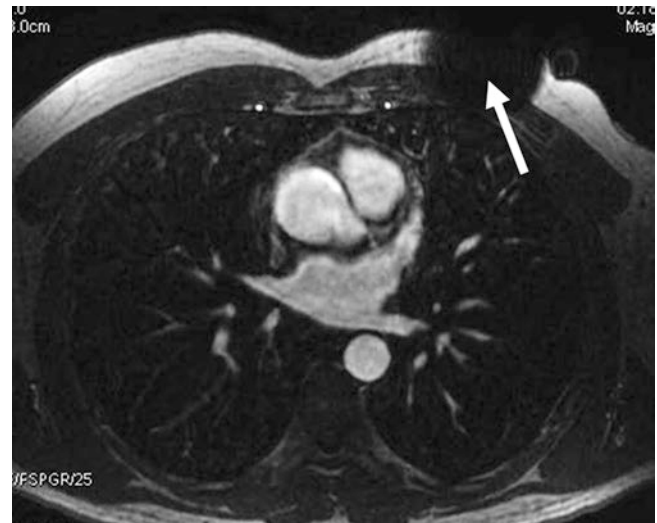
Axial MR image of a patient with a loop recorder imaged at 1.5 T. A local area of signal loss is visible near the area of subcutaneous implantation (*arrow*) (Courtesy of Dr. Gianluca Pontone, Centro Cardiologico Monzino)
